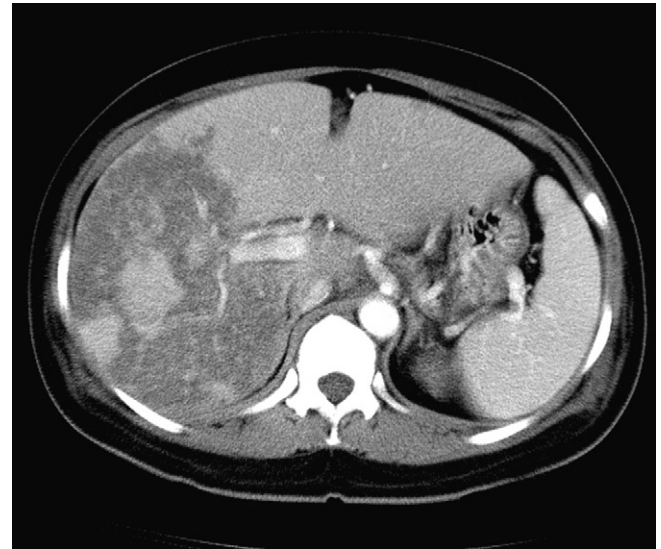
Contrast-enhanced CT axial image through liver and spleen shows geographically inhomogeneous wedge-shaped areas of low attenuation with mottled appearance and enhanced vessels coursing through these hypodense areas, mainly in the right hepatic lobe.
